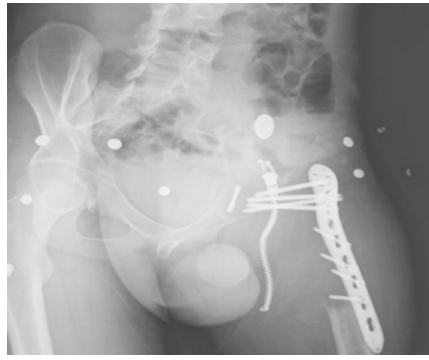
Direct radiograph 9 months after the second surgery
